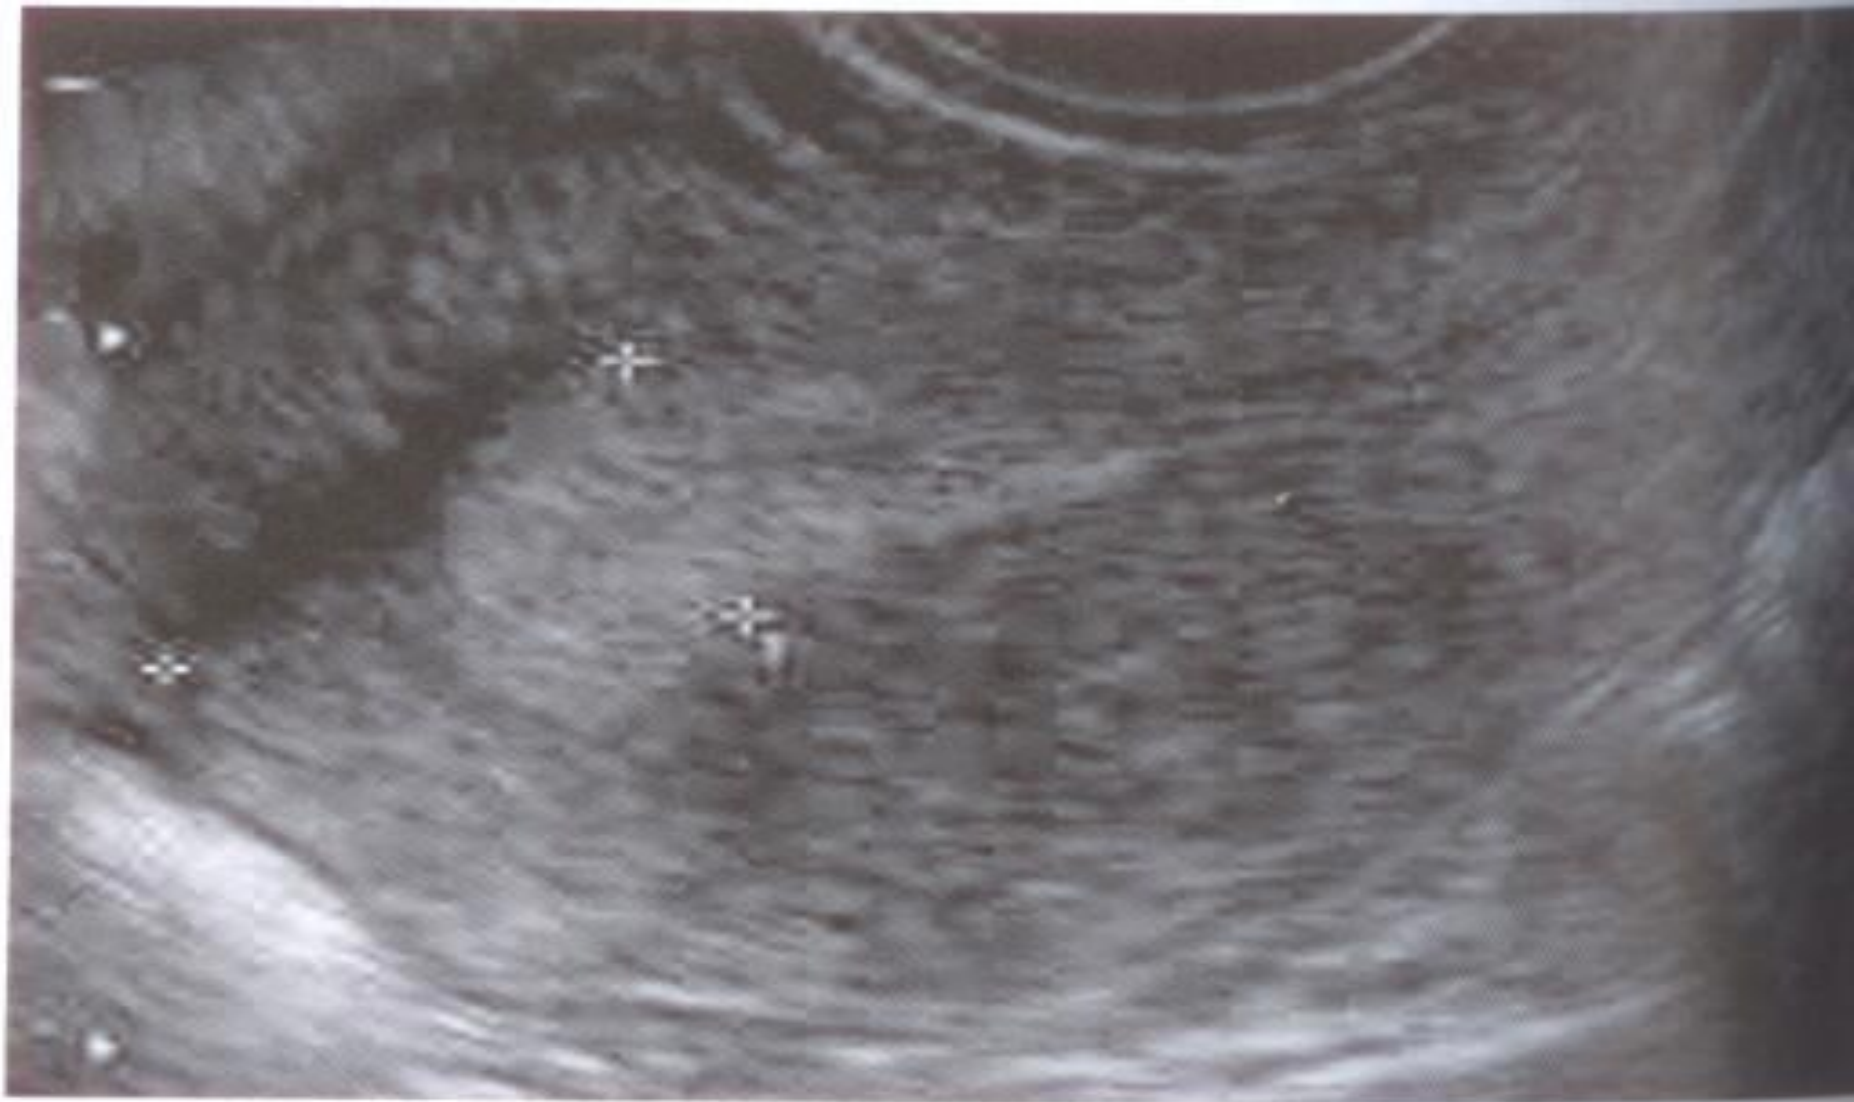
Transvaginal ultrasound image demonstrating thickened endometrium. (Courtesy of Dr C Hardwick, Glasgow.)
